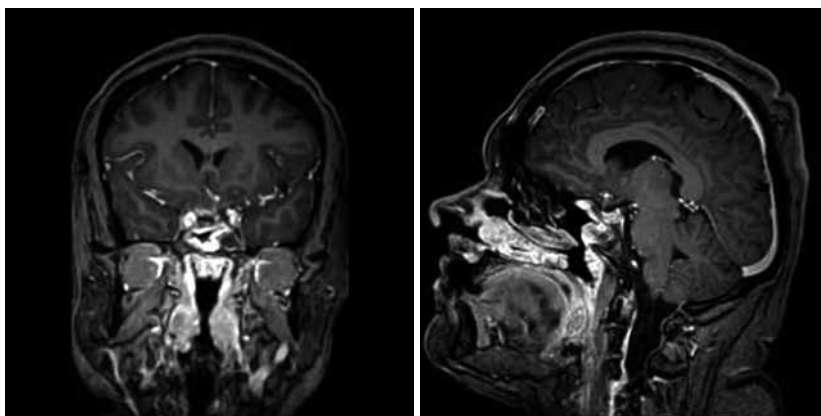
Postoperative control MRI of the brain, T1-weighted image with intravenous contrast
